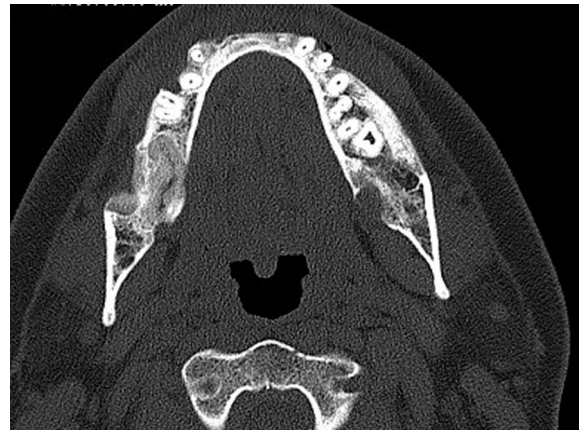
Post-op 6 months CT [axial section].
